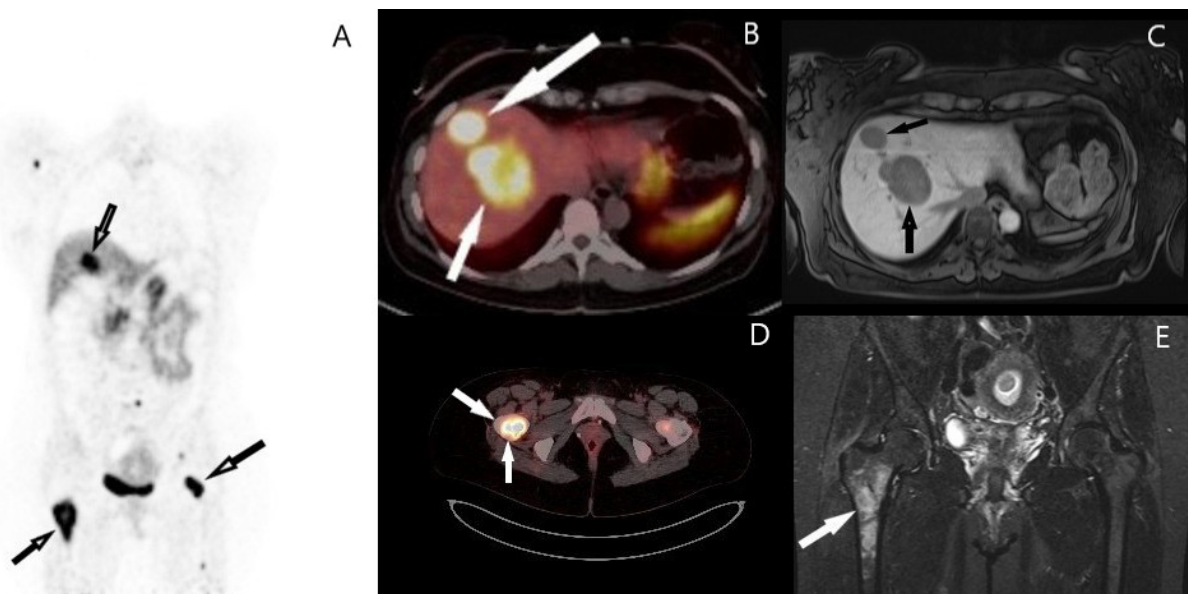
Heterogeneous metabolic response in ⁶⁸GA-DOTATATE PET/CT obtained 7 months after treatment. Obvious enlargement was noted in the high-grade somatostatin receptor expressing lesions in the VIII segment of the liver; Coronal view DOTA PET (A), DOTA PET fused axial image (B), Late liver phase postcontrast T1W axial MRI obtained with hepatospecific contrast agent (C). Partial regression was observed in the dimensions, T2A signal intensity and metabolic activity of right femoral metaphyseal metastasis; Fused posterior DOTA PET image (D), Coronal T2A FS MRI (E)
